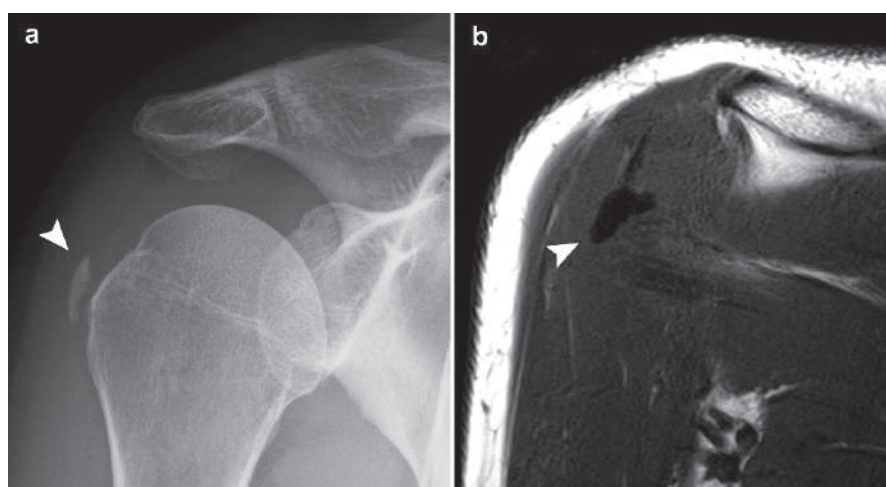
Plain radiograph of the shoulder (a) and T1W shoulder MRI (b) show calcification area within the infraspinatus tendon due to HADD (*arrowheads*)
